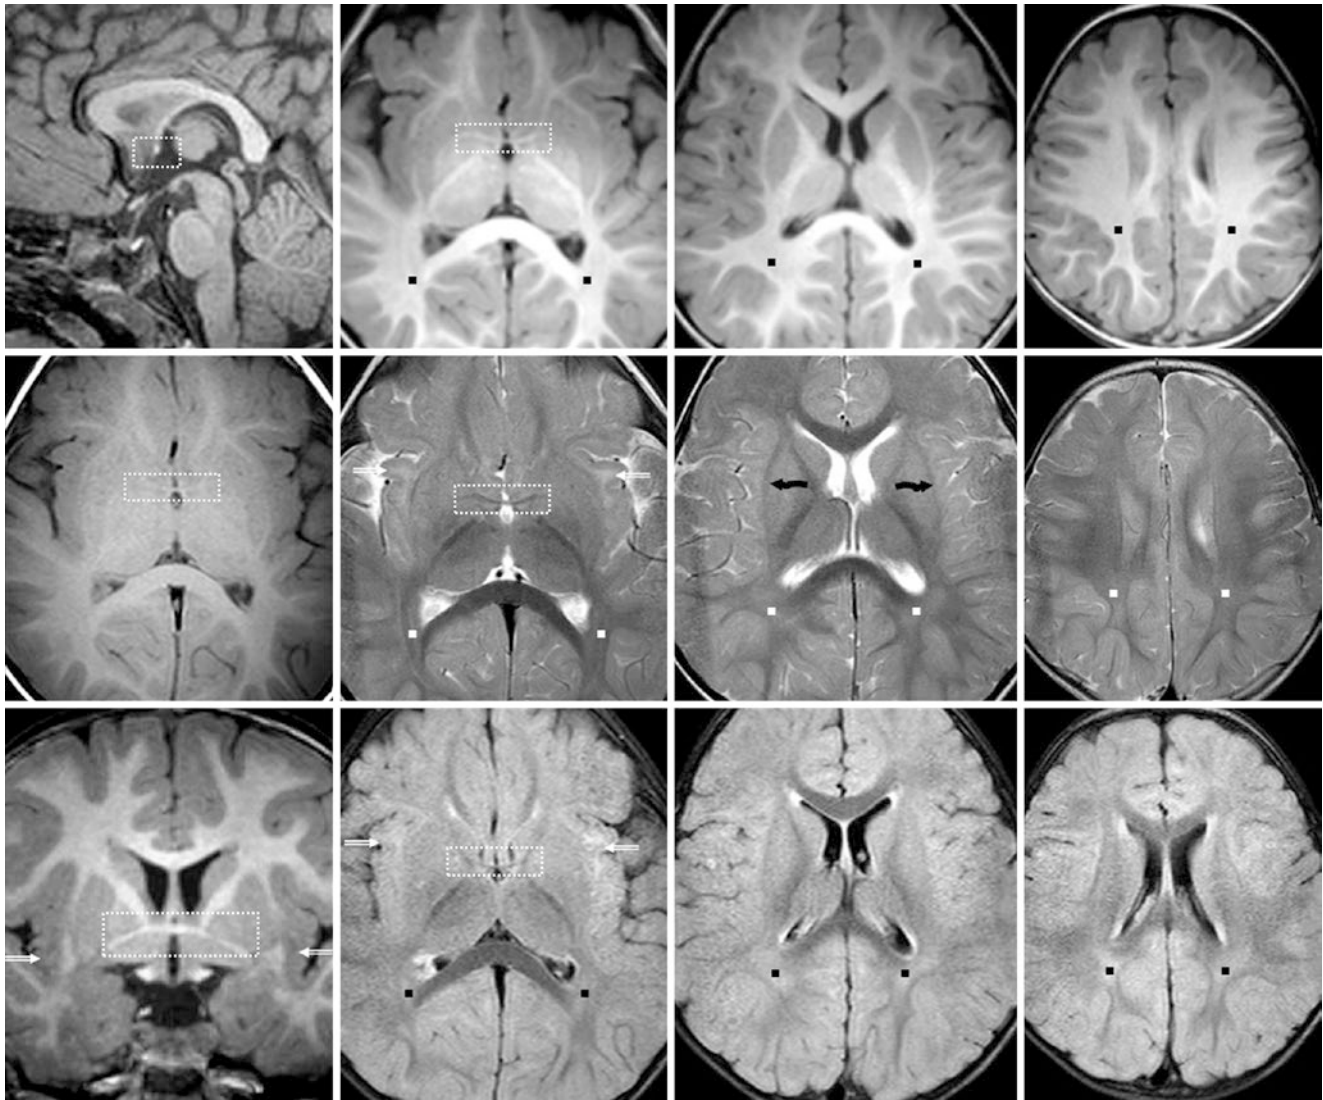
A 14-month-old with possible hypotonia and a negative 3T MRI. *Top row:* Sagittal (*left*) and axial (*right three images*) GE T1WIs show that the anterior commissure (*dotted boxes*) is mature. *Middle row:* An axial SE T1WI (*left*) does not show myelination as well. On SE T2WIs (*right three images*), note that the PVWM and the ECs (*crooked arrows*) are mature, with the exception of terminal zones
